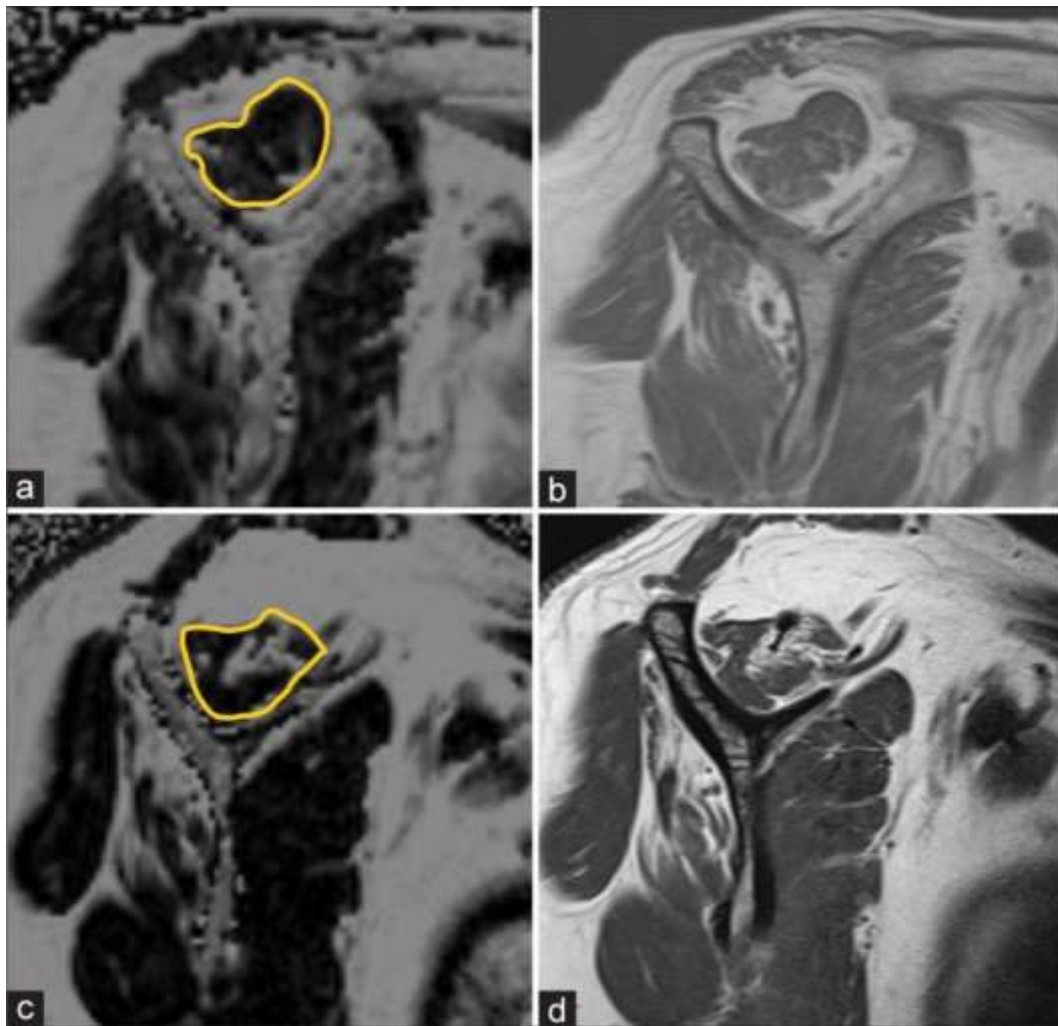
MRI images of the shoulder joint in a representative patient demonstrating rotator cuff pathology. Panels (a) and (c) show axial proton-density fat-saturated images with the supraspinatus tendon outlined, and panels (b) and (d) show corresponding coronal and sagittal sequences depicting tendon and muscle abnormalities.
